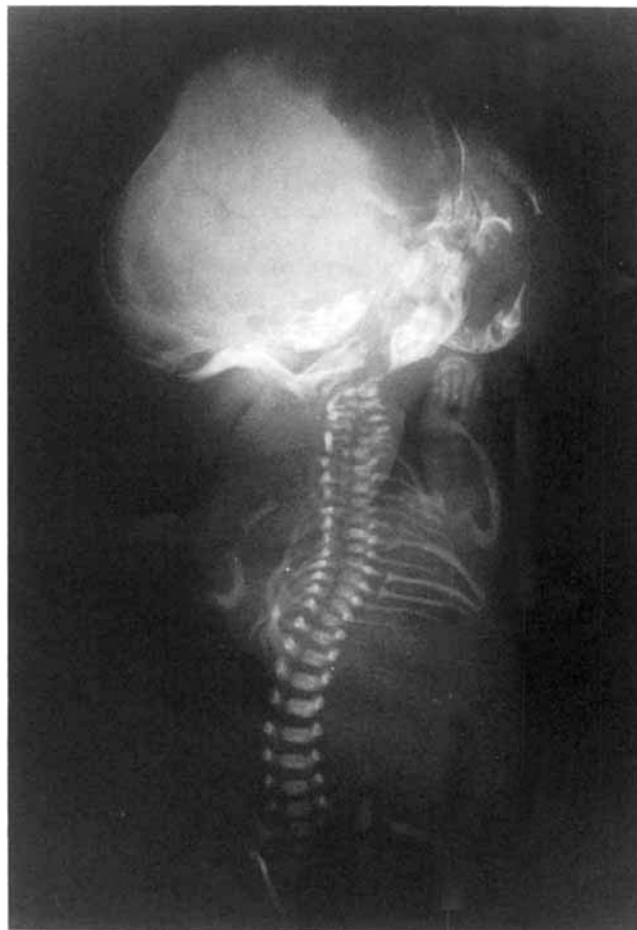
X-ray film of the fetus. Note the cranial bone defect and rudimentary scapula and pelvis.
